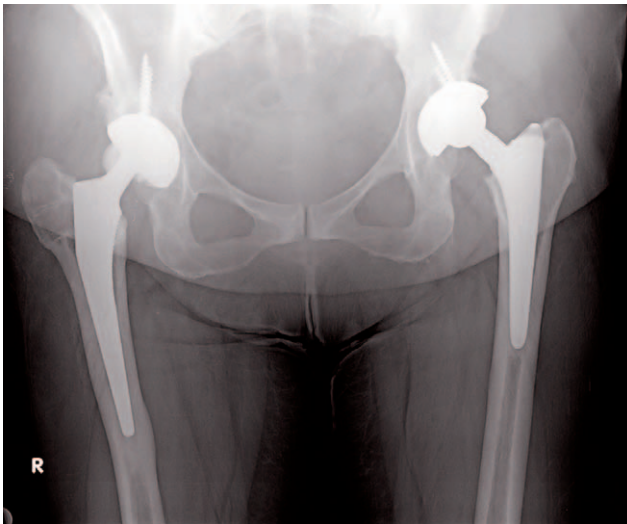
Pelvic anteroposterior radiography reveals the non-centralized position of the ceramic head in the acetabulum on the right side.
